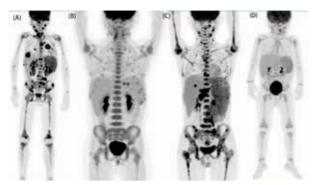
18F-FDG PET/CT maximum intensity projection of sHLH in 4 children. Hodgkin's lymphoma (A), CAEBV (B), EBV-HLH (C, D), presenting as hepatosplenomegaly and increased FDG uptake of spleen (A, B, C, D) and liver (A, C). (A) A 6-year-old boy with multiple enlarged lymph nodes (SUVmax:11.74, SUVmean:9.3); multiple focal increased FDG uptake in extranodal organs, including left external auditory canal skin, lungs, liver, kidney, right adrenal gland, small intestine, and bone marrow (SUVmax:11.16, SUVmean: 7.15). The child died three months later after admission. (B) An 8-year-old boy with multiple lymph nodes in the neck, supraclavicular and mediastinum, the FDG uptake was lower than that of the liver, SUVmax:1.83, SUVmean:1.54. FDG uptake of Bone marrow increased diffusely (SUVmax:4,01, SUVmean:3.65). There were multiple focal increased FDG uptake in the spleen. The children survived until the end of follow-up after hematopoietic stem cell transplantation. (C) A 14-year-old boy with multiple lymph nodes enlargement, increased FDG uptake and multiple focal FDG uptake in bone marrow. He was died of multiple organ failure. (D) A 2-year-old boy with multiple lymph nodes in the neck, supraclavicular, axilla, abdomen and groin, whose FDG uptake was slightly lower than that of the liver. He was still alive until the end of follow-up.
